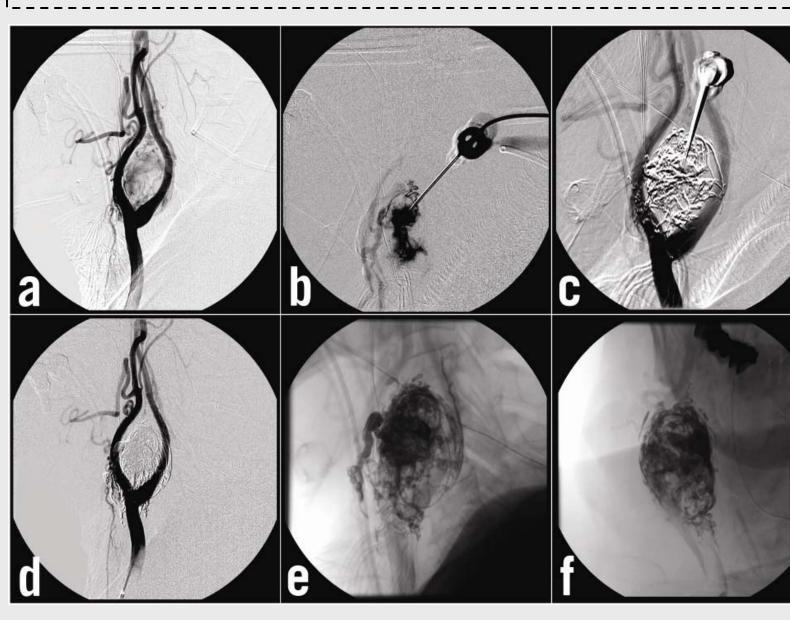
A 70-year-old male presented with a right sided soft, pulsatile neck mass. MRI demonstrated a salt-and-pepper lesion and an octreotide scan demonstrated marked uptake consistent with a CBT. The patient underwent a diagnostic angiogram demonstrating a highly vascular tumor splaying the internal and external carotid arteries (Figure 1 a). Tumor embolization was then performed via direct puncture using Onyx 34 (Figure 1b and c). Post-embolization Figure 2. Close-up of angiography demonstrated complete devasculari- Onyx after tumor zation of the tumor (Figure 1 d-f).
